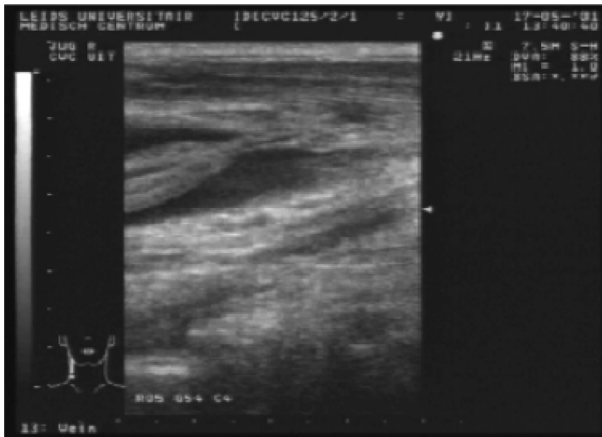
Ultrasonic appearance of a typical enveloping ‘fibrin sheath’ demonstrated immediately after central venous catheter removal (Jugular vein).
